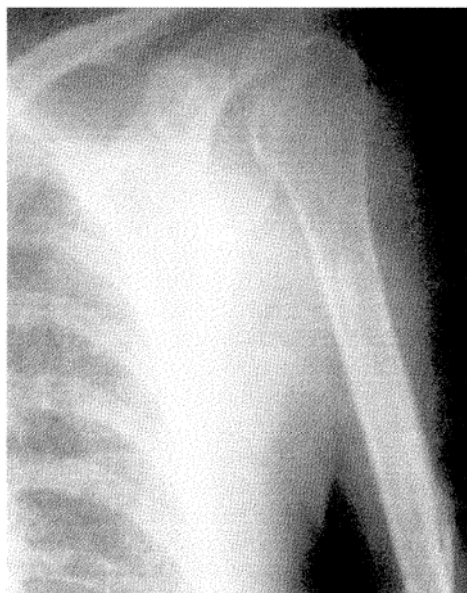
Radiograph of shoulder with lytic lesions.
